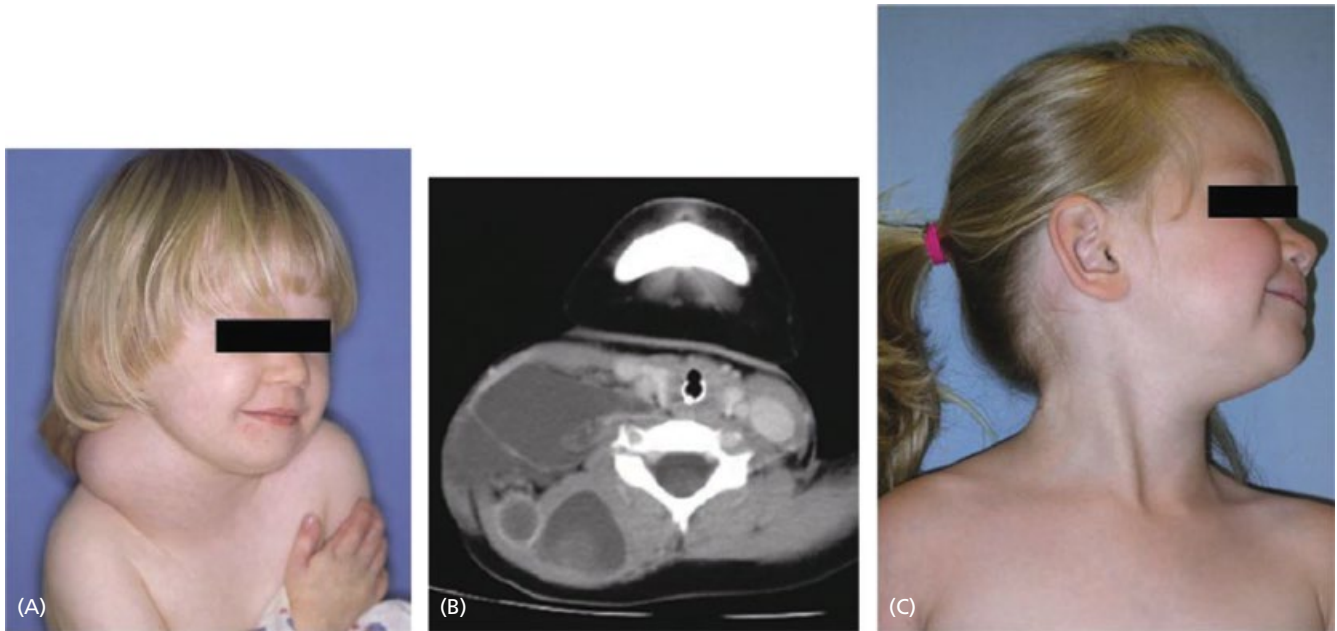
Macrocystic lymphatic malformation of the neck and right upper extremity, treated with direct injection of ethanol and then four sessions of OK-432 injection. The ethanol injections were ineffective, but the OK-432 injections resulted in complete regression of the mass. (A) Clinical photograph before OK-432 sclerotherapy showing a large focal right neck mass. (B) Axial CT scan after intravenous contrast medium injection showing macrocysts in the right neck. The thick-walled cyst was previously injected with ethanol. (C) Clinical photograph taken 1 year after four injections of OK-432 showing complete regression of the right neck mass. *Source:* Reproduced from Burrows and Mason [309] with permission of Elsevier.
